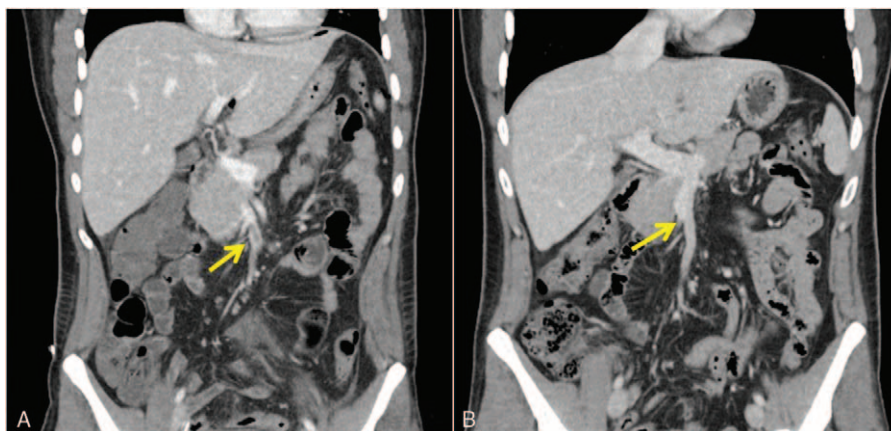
CT scans of patient 3 (A) 1 week after surgery and (B) after 2 months of anticoagulation.
